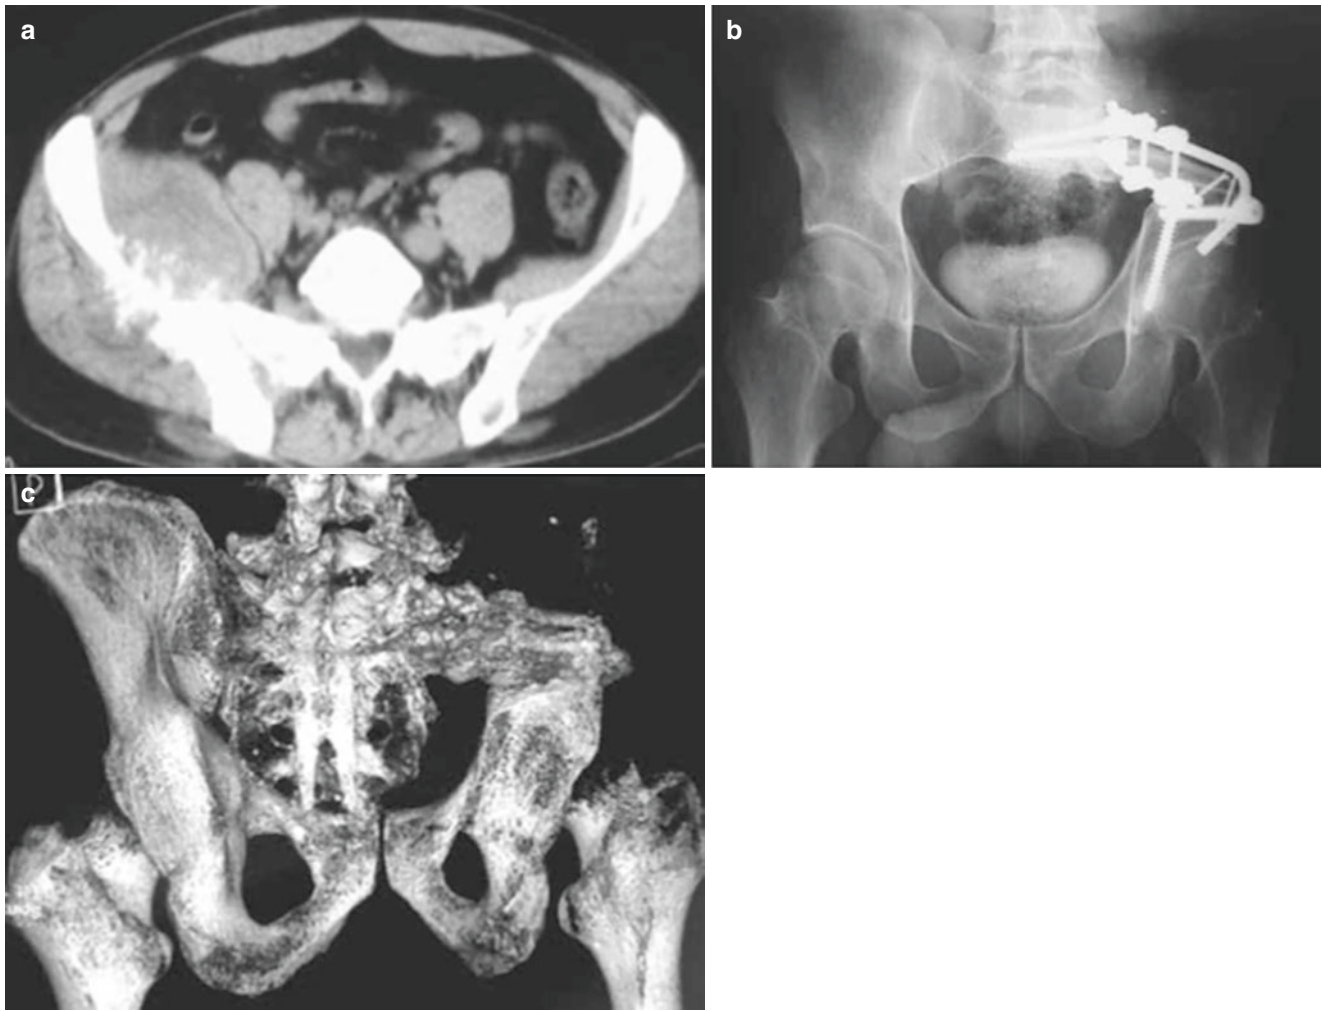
(a) Preoperative radiologic workup image suggests a mass involving the right iliac bone and sacroiliac joint. (b, c) Radiographs and 3D CT scans 3 years after type I + IV pelvic resection
